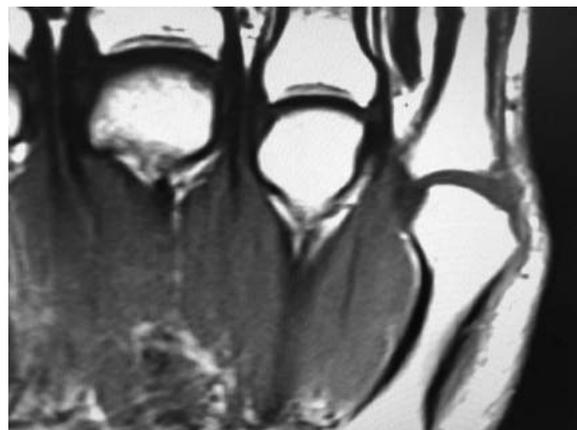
MRI of the third, fourth, and fifth MCP joints. Note the complete tear of the UCL of the fifth MCP joint with uncovering of the MCP head and radial deviation of the proximal phalanx.
